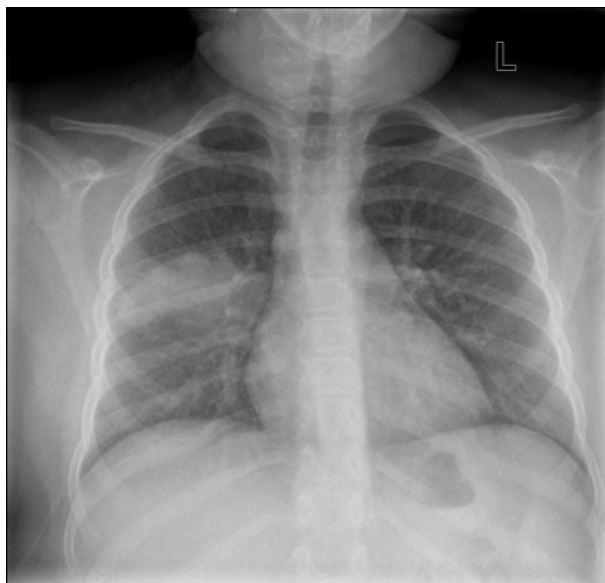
Radiographic findings of pneumococcal pneumonia: Rounded area of airspace consolidation in the superior segment of the right lower lobe. A few air bronchograms are seen medially.
